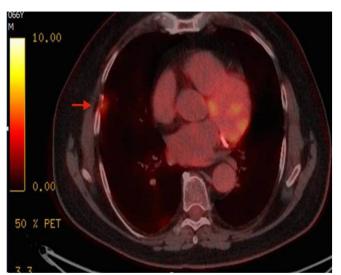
PET-CT revealing avidity of the right middle lobe nodule with an SUV of 3.6.
